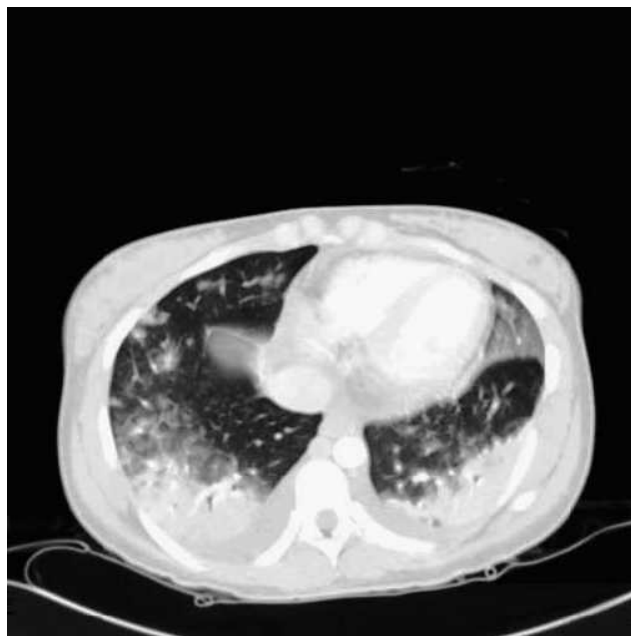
Computed tomographic scan revealing bilateral basilar pulmonary consolidation, consistent with pneumonic infiltrates.
